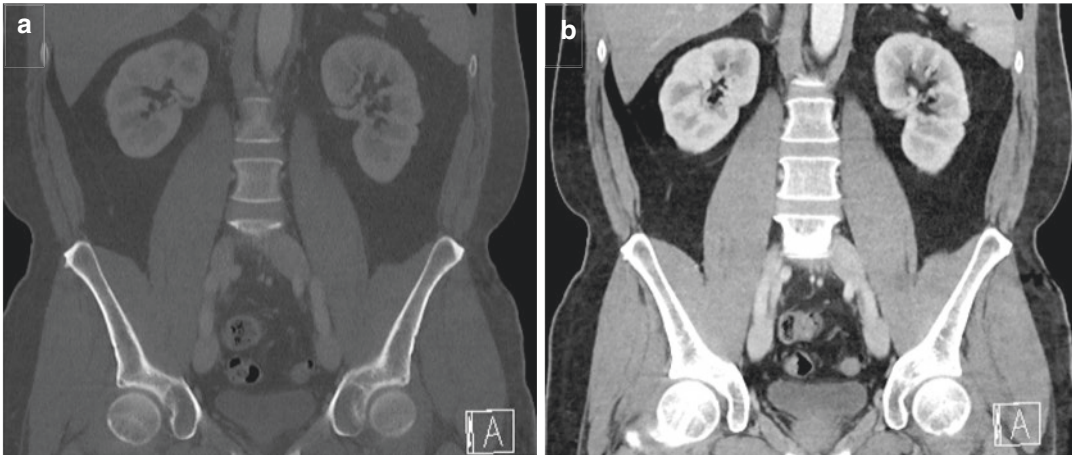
Computed Tomography (CT) imaging of normal kidneys. Coronal CT scan of the normal kidneys and bladder—without contrast (a) and following administration of iodinated contrast (b)
